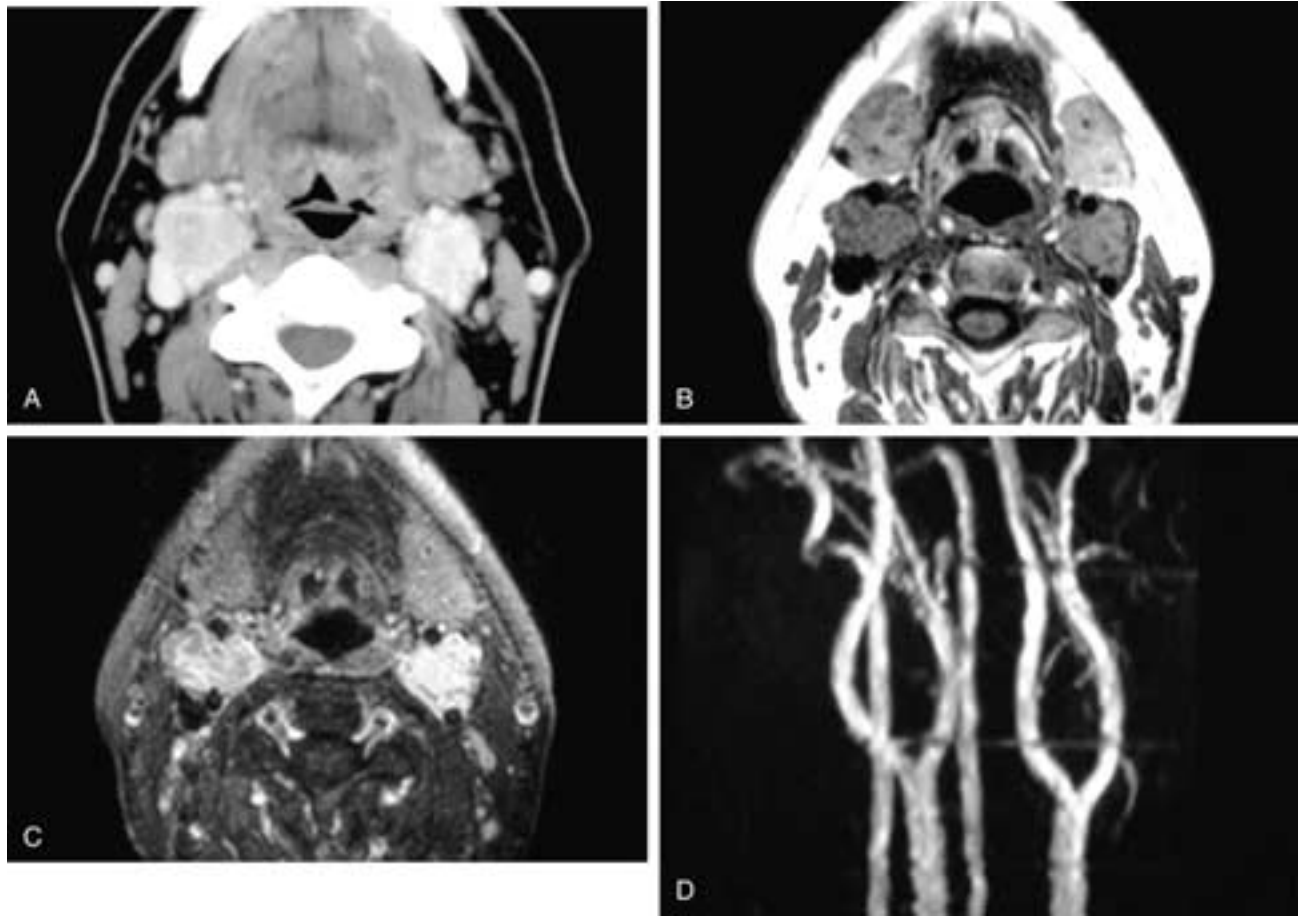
Axial contrast-enhanced CT scan (A) shows bilateral enhancing ovoid masses that splay the carotid arteries. Axial T1-weighted MR image (B) shows the bilateral carotid body tumors to have virtually no vascular flow voids. A T1-weighted, fat-suppressed, contrast-enhanced MR image (C) shows marked enhancement of the tumors. A left anterior oblique projection of an MRA (D) shows the splaying of both carotid bifurcations but virtually no tumor vascularity. On a conventional arteriogram, these tumors each had dense hypervascularity.
